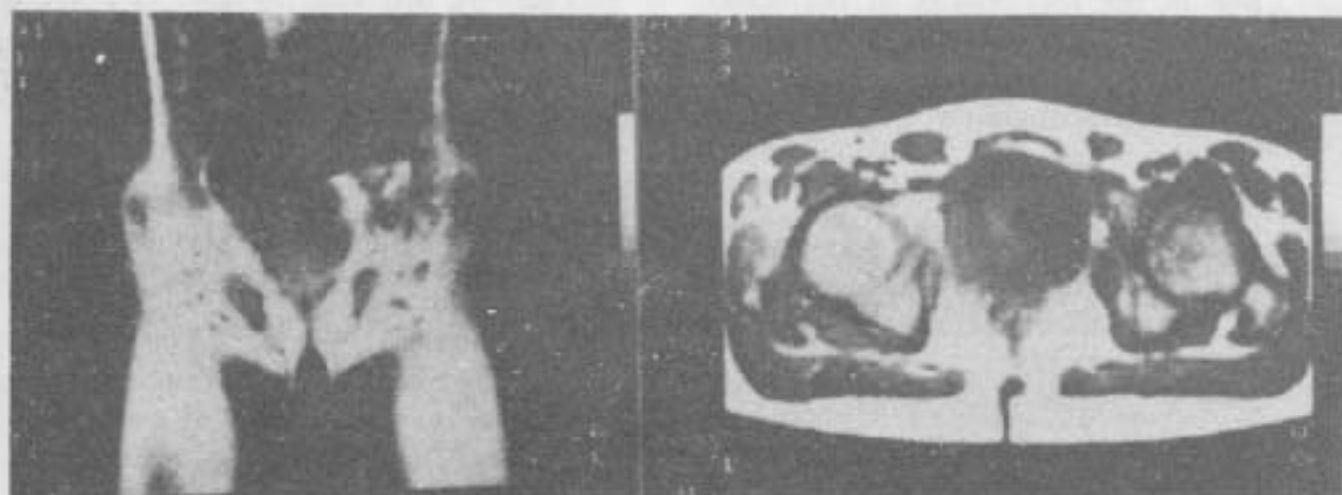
T1-weighted (SE/TR/20/500 m secs).
